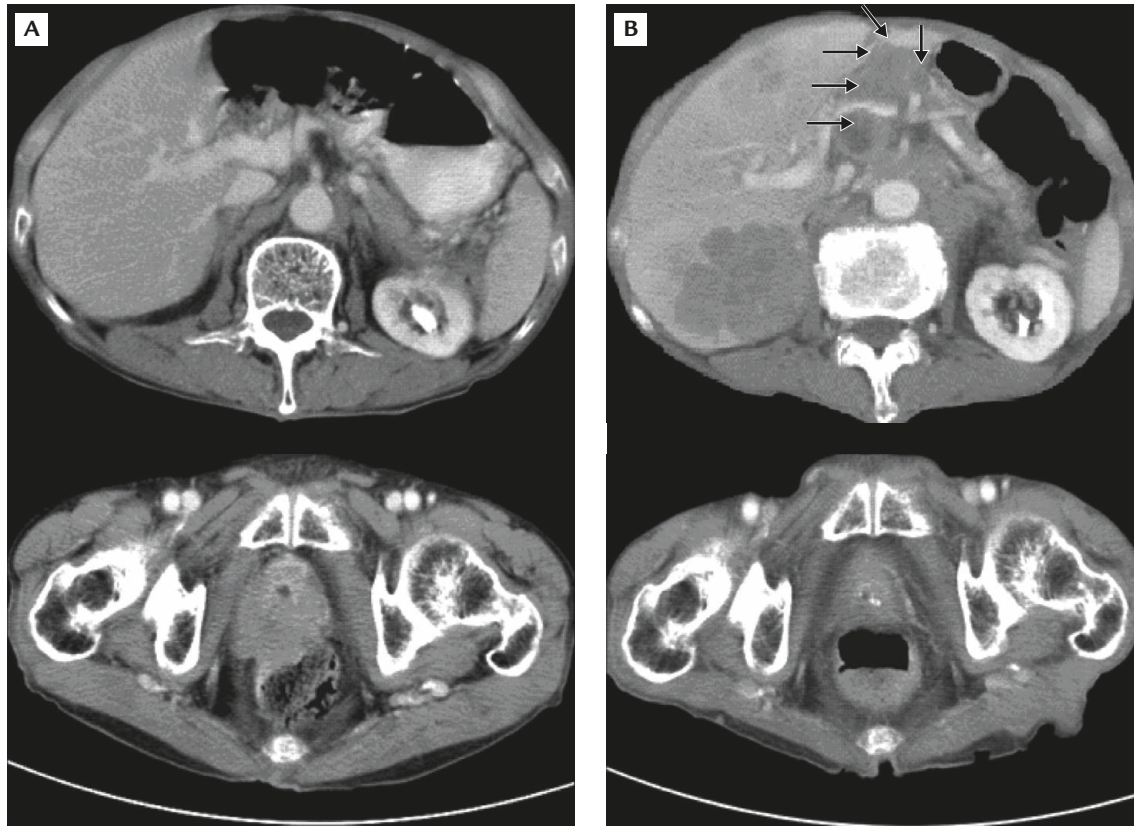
(A) Abdominal computed tomography in April 2007 shows an enlarged prostate gland with low attenuation nodules. (B) Abdominal computed tomography 1 year later in April 2008 shows progression to retroperitoneal lymph node and liver metastasis with duodenal invasion (arrows).
